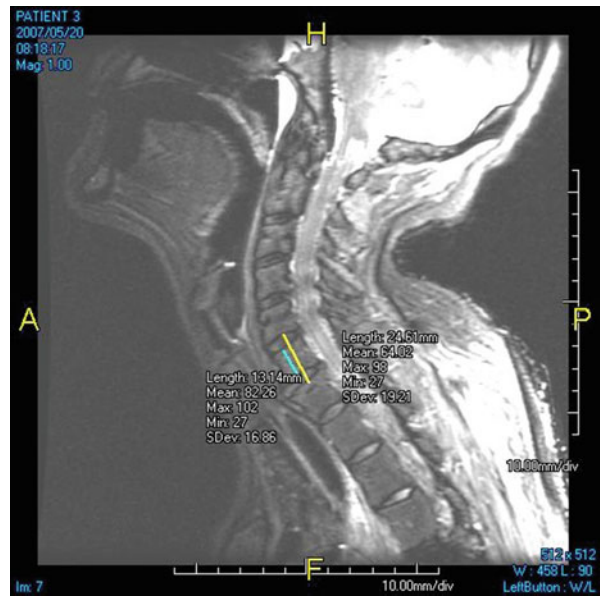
Comparison of MR images at different bandwidths (BW). (a) T2 FSE image – single level. (b) T2 FSE image – single level and higher bandwidth
